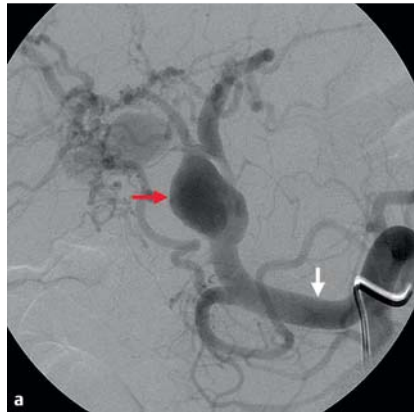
a An angiogram performed immediately after the computed tomography (CT) scan confirms the pseudoaneurysm (red arrow) arising from a replaced hepatic artery (white arrow) off the superior mesenteric artery. b Post-embolization arteriogram of the common hepatic artery, demonstrating occlusion of the two large pseudoaneurysms.
